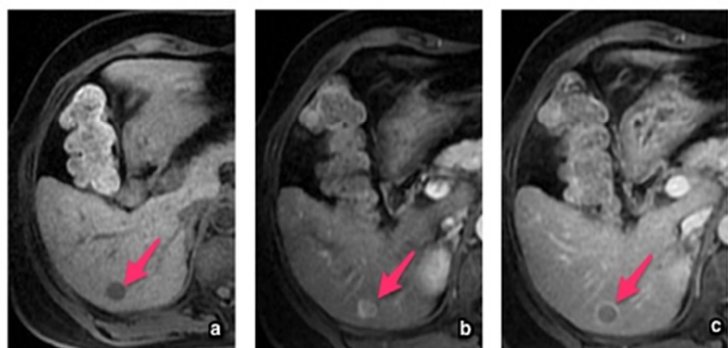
A 45-year-old female with a small HCC in S6 (arrow) showed on unenhanced combined enhanced MR imaging (a: unenhanced T1 weighted image, b: arterial phase, c: delayed phase). Both of the 2 readers categorized this lesion as an arterial phase hyper-enhanced lesion, with washout and capsule appearance, and with a diameter of 1.3cm. Thus, according to LI-RADS 2014, both of the 2 readers categorized this lesion as LR 5.
